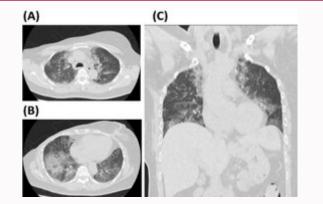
Findings on computed tomography: Diffuse ground glass opacities, improved after treatments compared to previous image studies (A, B) Transverse view (C) Sagittal view.
